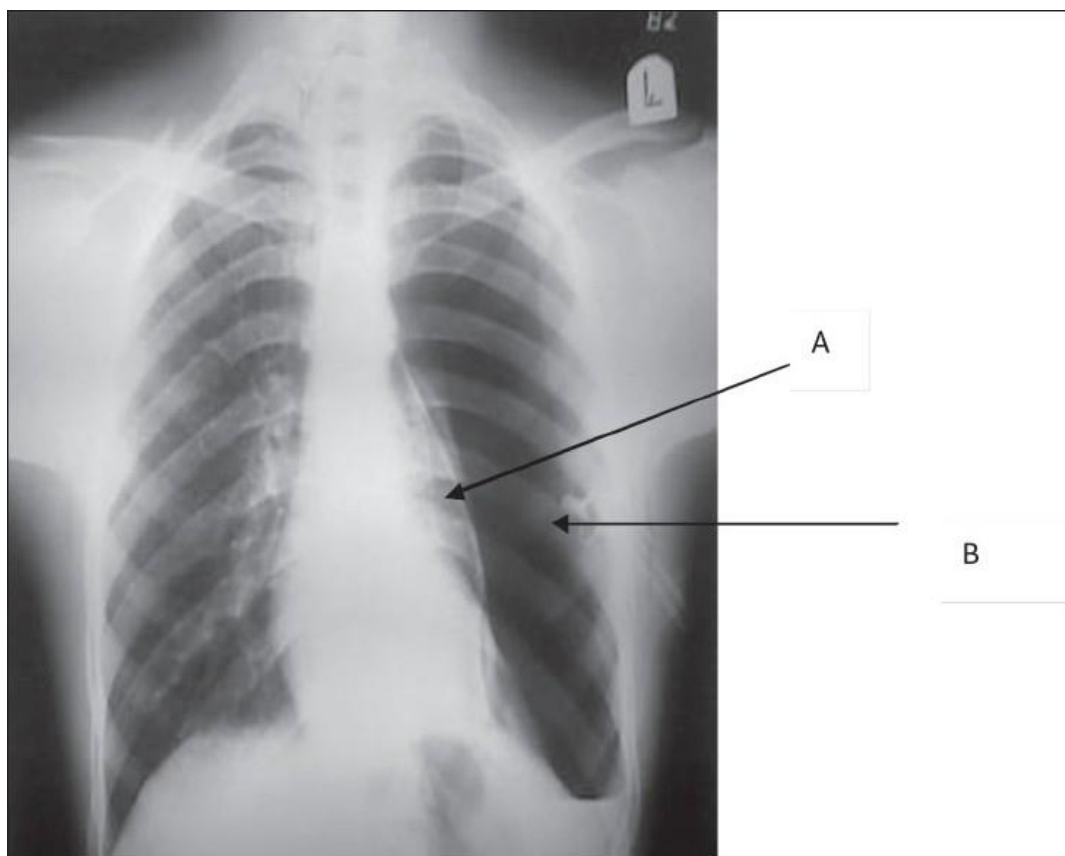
Chest X-Ray showing pneumothorax secondary to blocked chest tube. A. Pleural white line B. Blocked chest tube ⁽³⁰⁾
